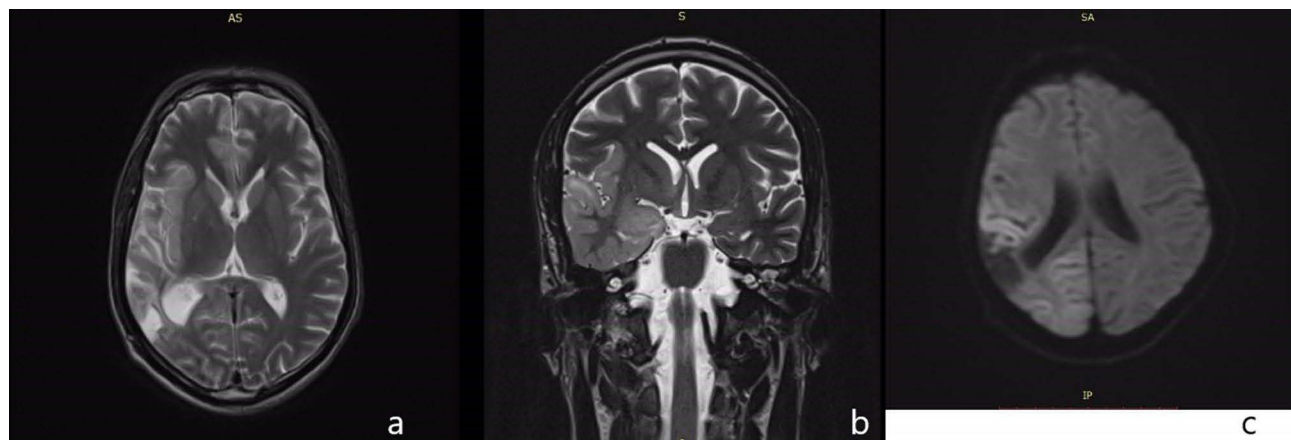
(a) Axial T2W (b) Coronal T2W (c) Axial DWI.
